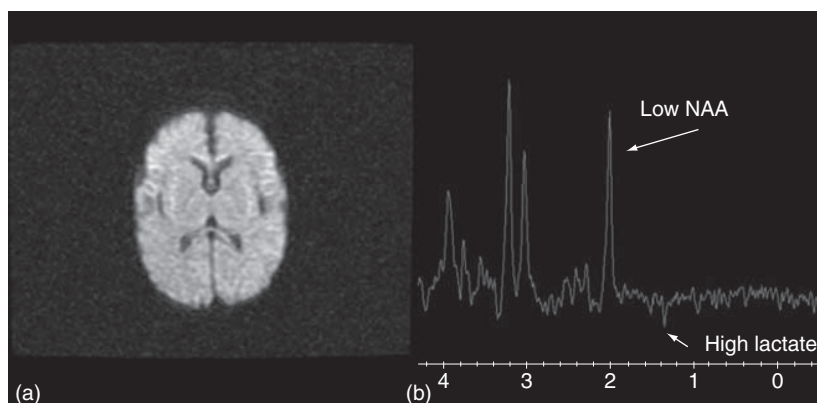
(a) Diffusion brain MRI of a newborn at the onset of the disease showing normal results. (b) Despite normal brain MRI high lactate and low *N*-acetylaspartate (NAA) peaks are pointing toward metabolic decompensation.
